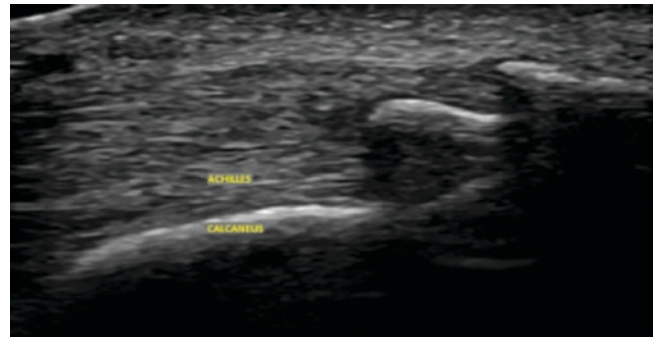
Long axis ultrasound view of chronic Achilles tendonitis with enthesophyte irregularity and calcifications at the Achilles tendon insertion. (Reproduced from Benjamin et al. [61])
